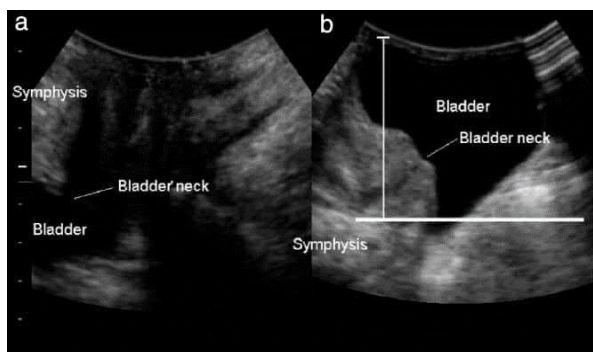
(1). cystocele ultrasound.
